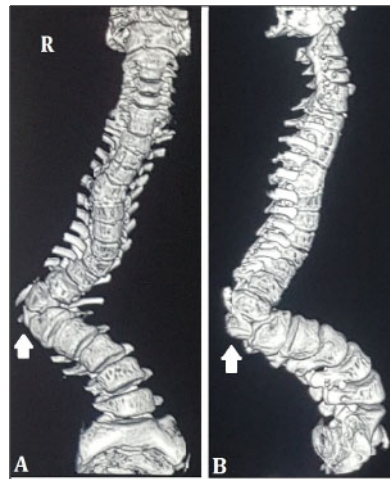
Preoperative 3D CT surface reconstruction of vertebral column showing kyphoscoliotic deformity with right sided convexity (arrow pointing towards D12 hemivertebra).
